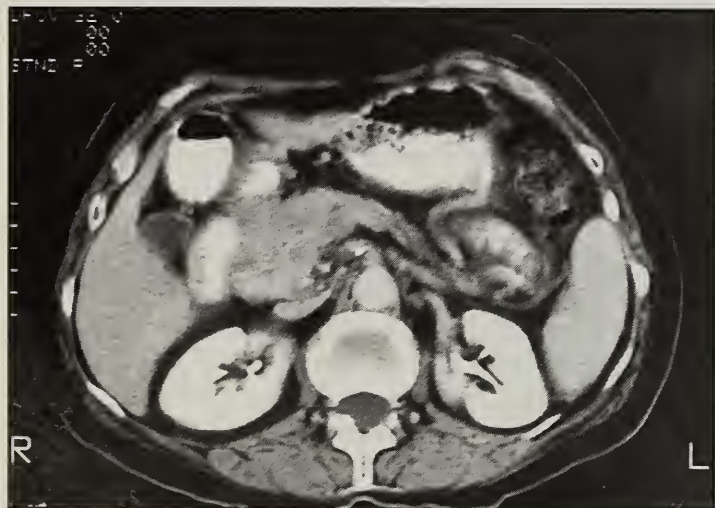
CT scan of abdomen showing large mass in head and body of pancreas.
